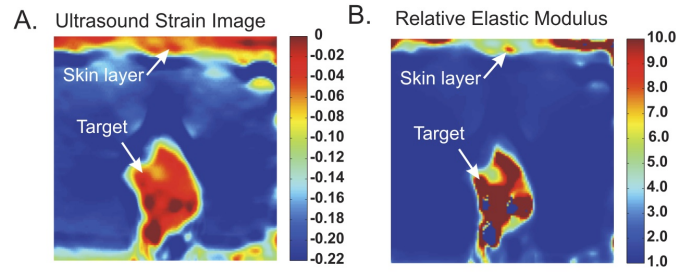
Ultrasound elastography was used to obtain elastic moduli for input into the FE model. A. Axial strain image obtained from ultrasound elastography. B. Relative elastic modulus distribution calculated from the strain image using the inverse FE approach described in section II-B.
